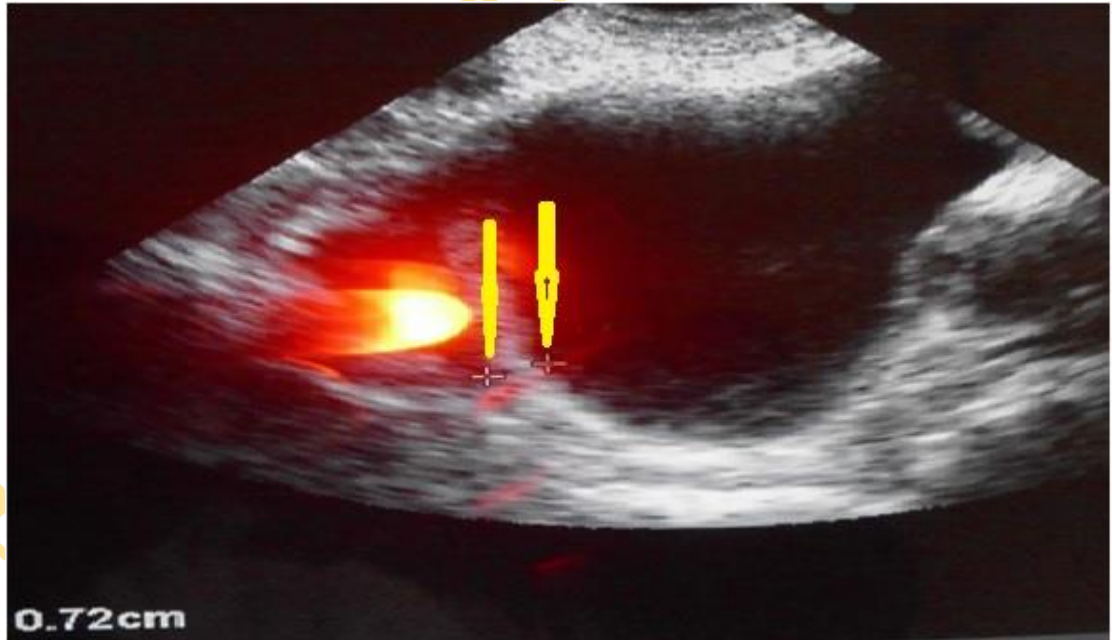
A B mode ultrasound of the bladder showing a thickened bladder wall (arrows)
